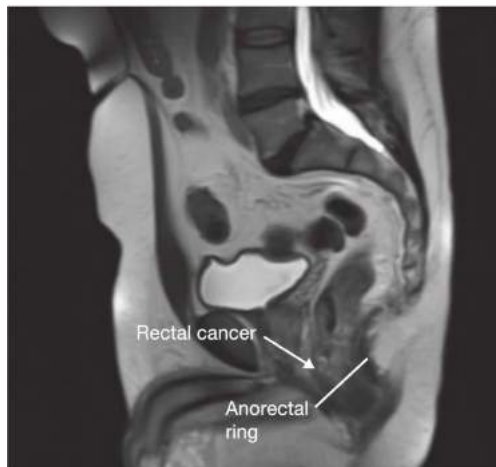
• Pre-neoadjuvant treatment MRI of a rectal cancer suitable for TATA.
